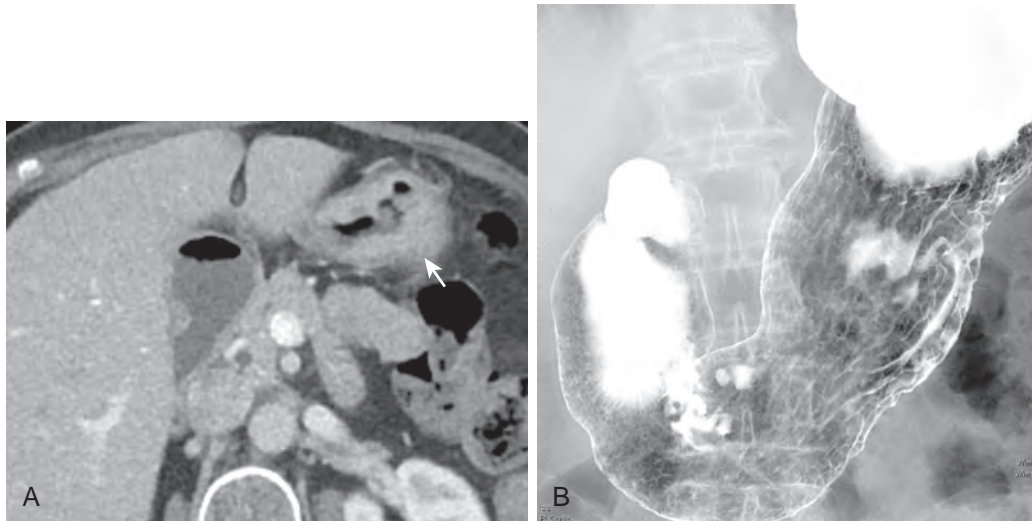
False-positive MDCT for gastric carcinoma. A. Representative axial MDCT scan shows a focal area of apparent wall thickening (arrow) on the greater curvature of the gastric body that is worrisome for an infiltrating tumor. B. A frontal view of the stomach from a subsequent double-contrast upper GI examination shows a normal-appearing stomach without any findings to suggest tumor in the gastric body. In patients with known gastric cancer, the accuracy of MDCT can be improved by using appropriate technique to ensure that the stomach is maximally distended. Nevertheless, it is not always possible to achieve optimal gastric distention on routine abdominal CT.
